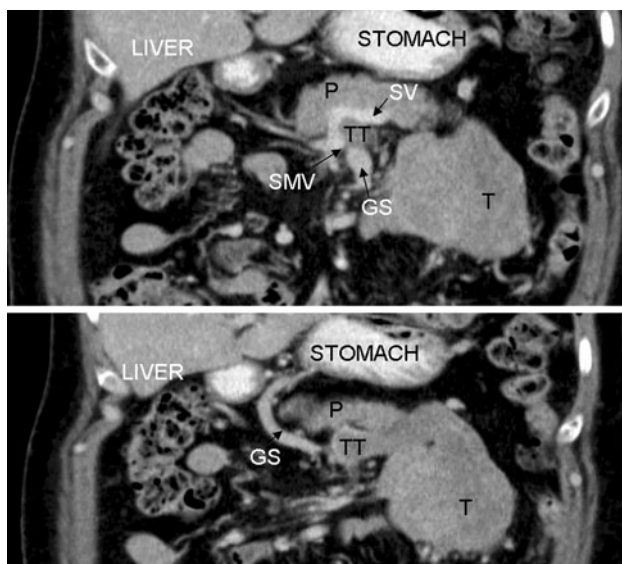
Preoperative CT scan showing tumour thrombus (*TT*) protruding into the splenomesenteric angle. Superior mesenteric vein (*SMV*), splenic vein (*SV*), gastroepiploic shunt (*GS*), pancreas (*P*) and main tumour lesion (*T*)
